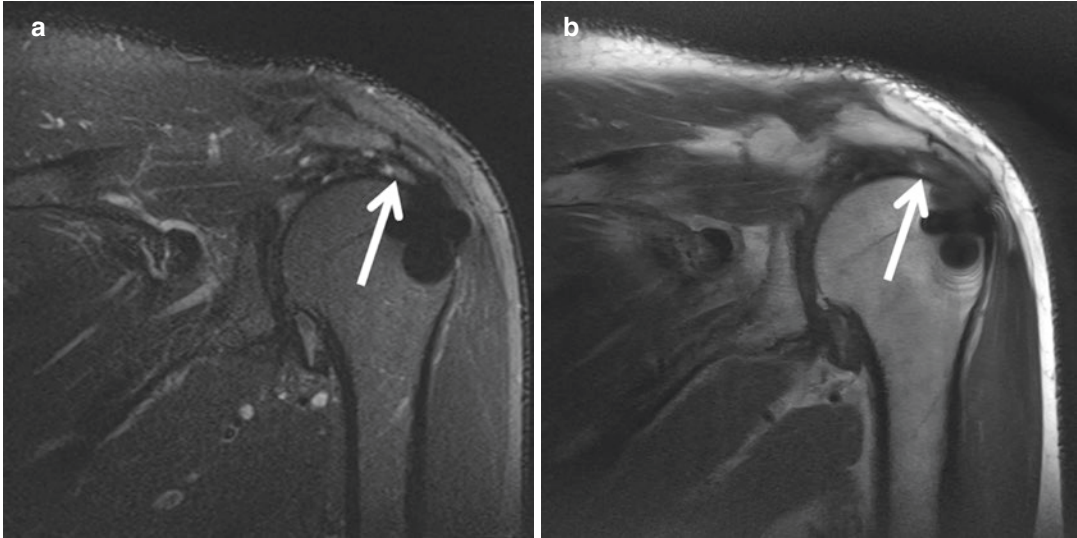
Postoperative partial-thickness rotator cuff tear. (a) Coronal oblique STIR and (b) proton density MR images demonstrate fluid signal intensity and discontinuity
